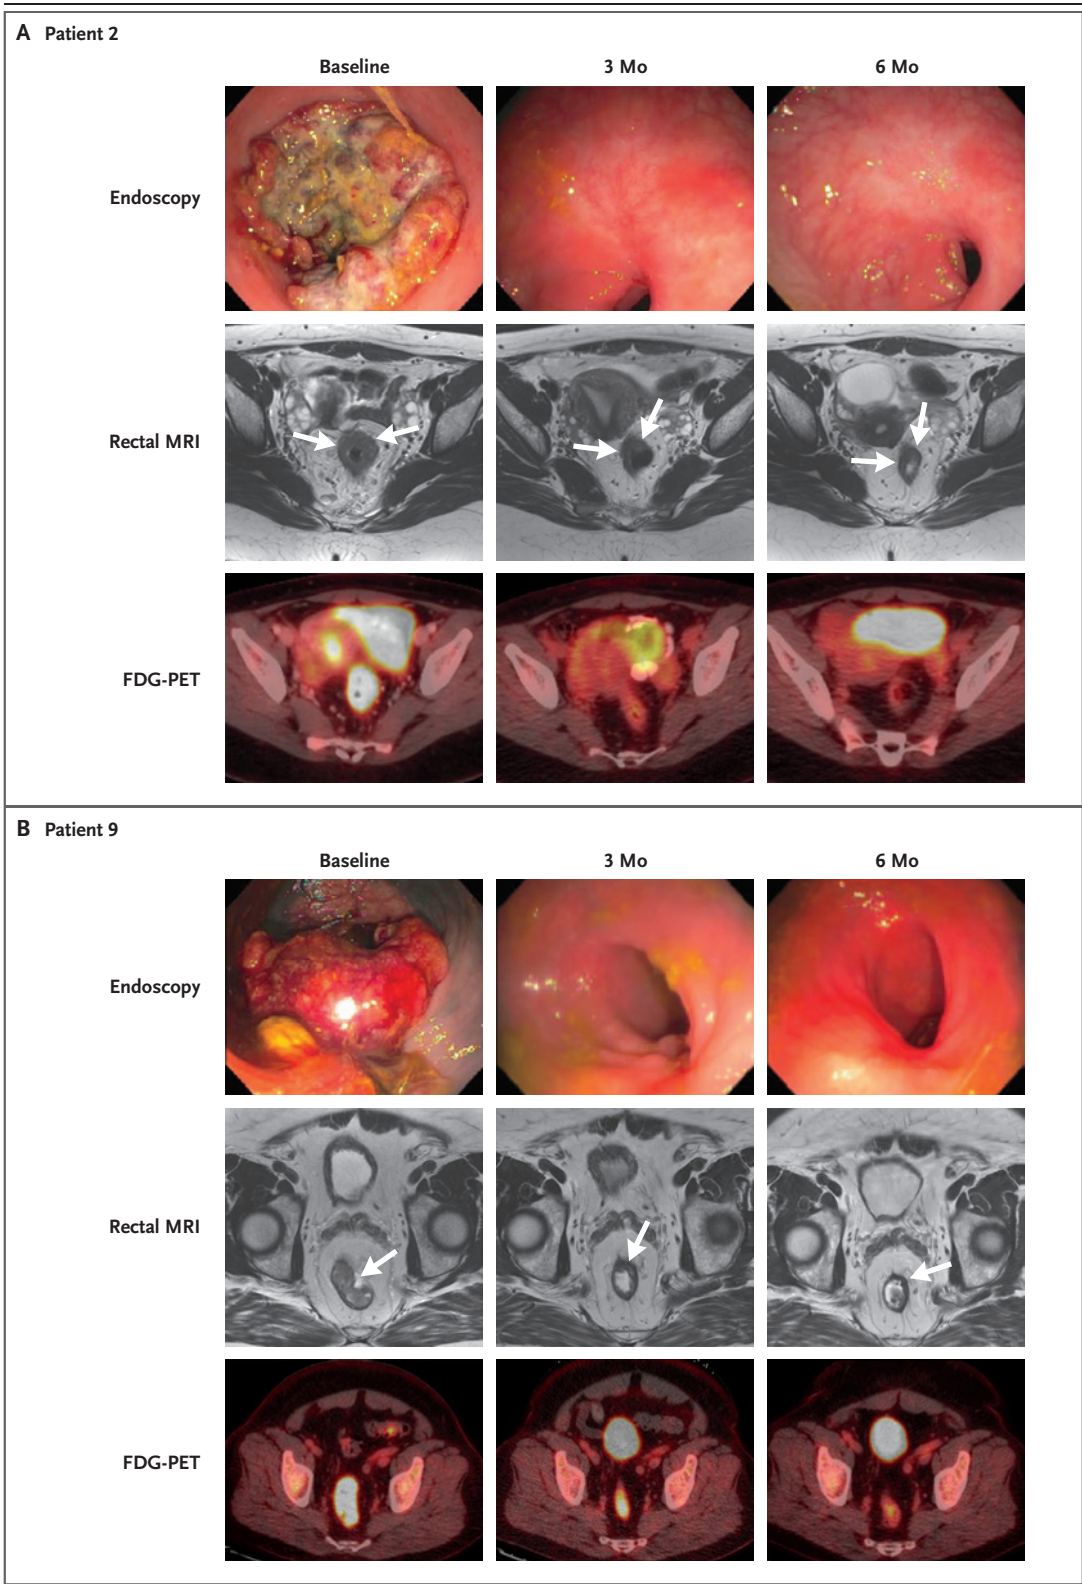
(facing page). Evolution of Endoscopic and Radiographic Response in Representative Patients Treated with Dostarlimab.
